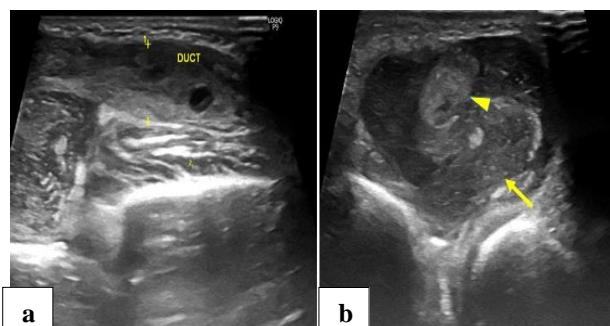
Local ultrasound of the left cheek
